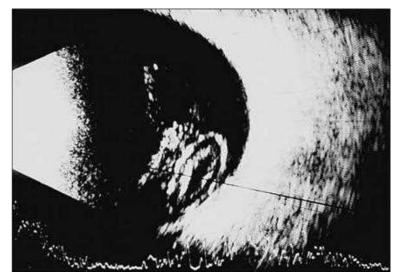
Dropped Nucleus. B-scan ultrasonography 1 day after dislocation of a lens nucleus into the vitreous cavity in a patient with high myopia.
